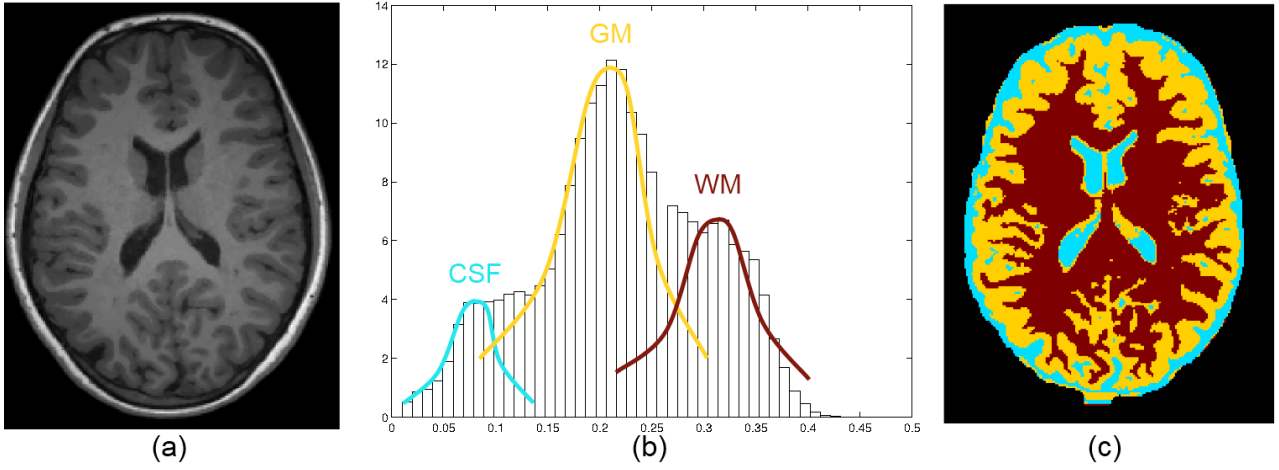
Shows a structural MRI in (a), and the initialisation of CSF, GM and WM distributions obtained from the peak-finding algorithm on the intensity histogram of the image in (b). The resulting segmentation using this initialisation is shown in (c).
